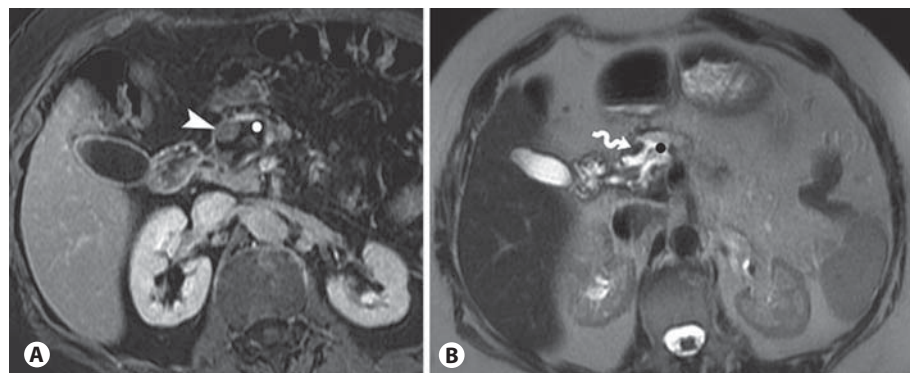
Contrast-enhanced T1-weighted MRI, delayed phase (A) demonstrates the dilatation of the main pancreatic duct (white disc on A and black disc on B), as well as the presence of the solid nodule in the MPD (arrowhead) with moderate contrast uptake. This nodule appears hypointense (arrow) on the T2-weighted sequence (B).
